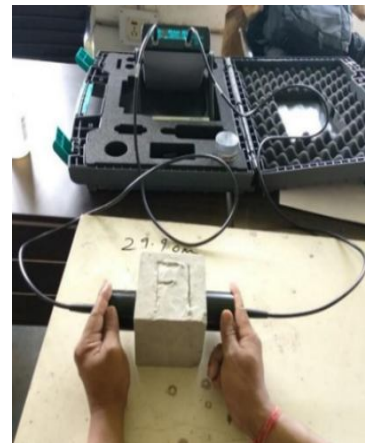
Ultrasonic pulse velocity test
